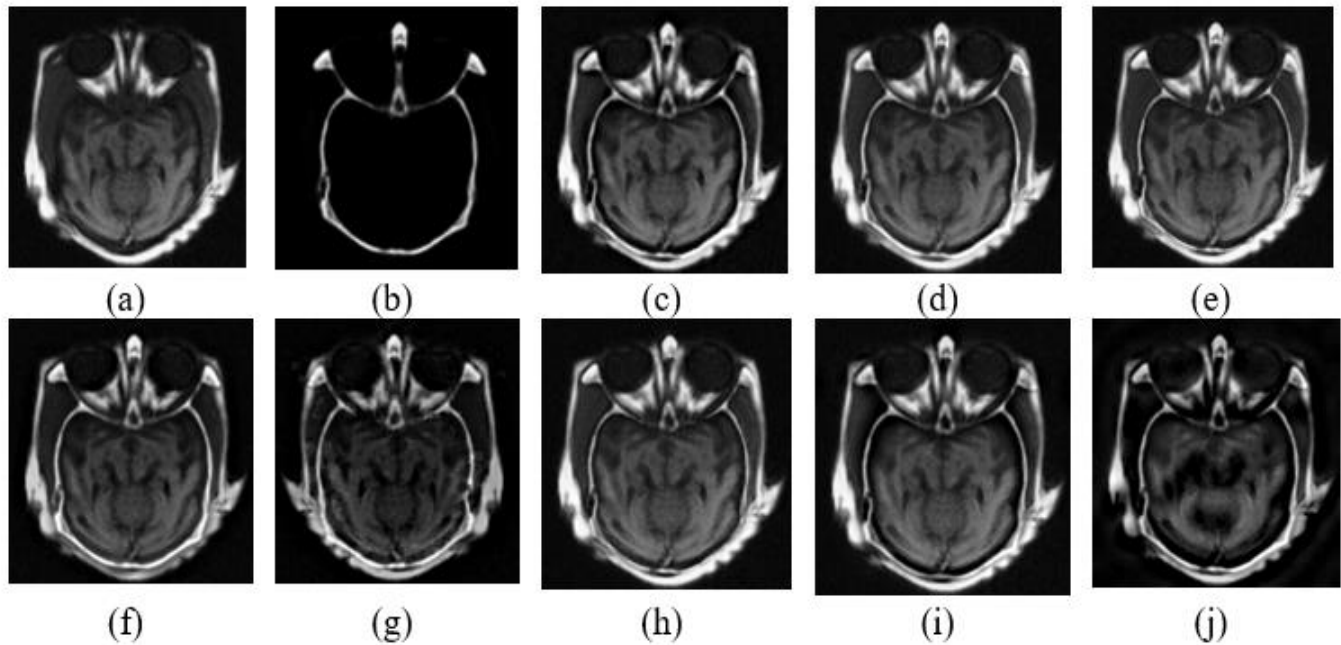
Qualitative results for MRI/CT images. Dataset 1 (a) MRI image, (b) CT image, (c) LEGFF, (d) FGF-XDoG, (e) MDHU, (f) FDO-DPGF, (g) CSMCA, (h) S-ADE, (i) PCLLE NSCT, (j) NSST AGPCNN.
